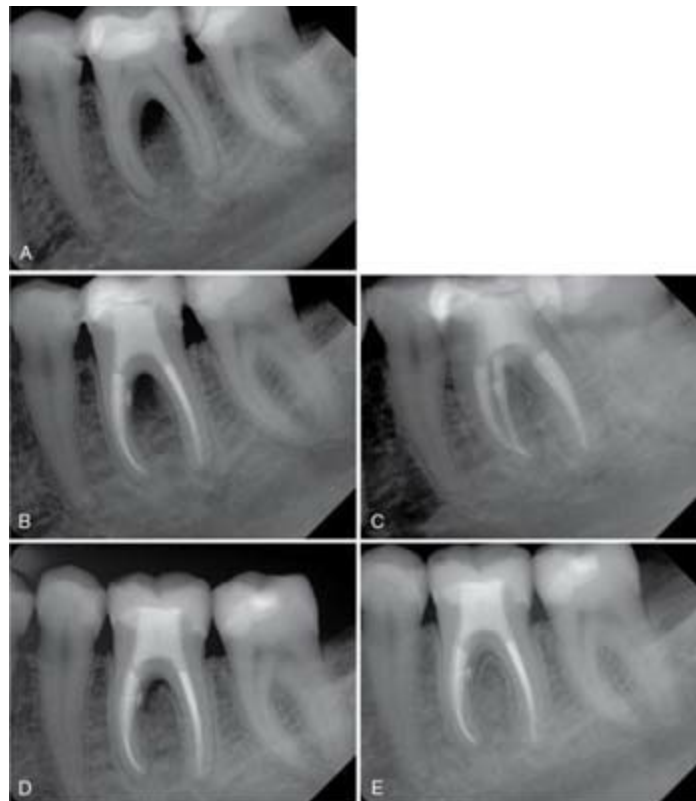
Root canal treatment in a case of apical and interradicular pathosis. A, Pretreatment radiograph of tooth #19 shows an interradicular lesion. B–C, Posttreatment radiographs after root canal preparation and obturation. Note the lateral canal in the coronal third of the root canal. D–E, Two-month recall radiograph suggests rapid healing.
